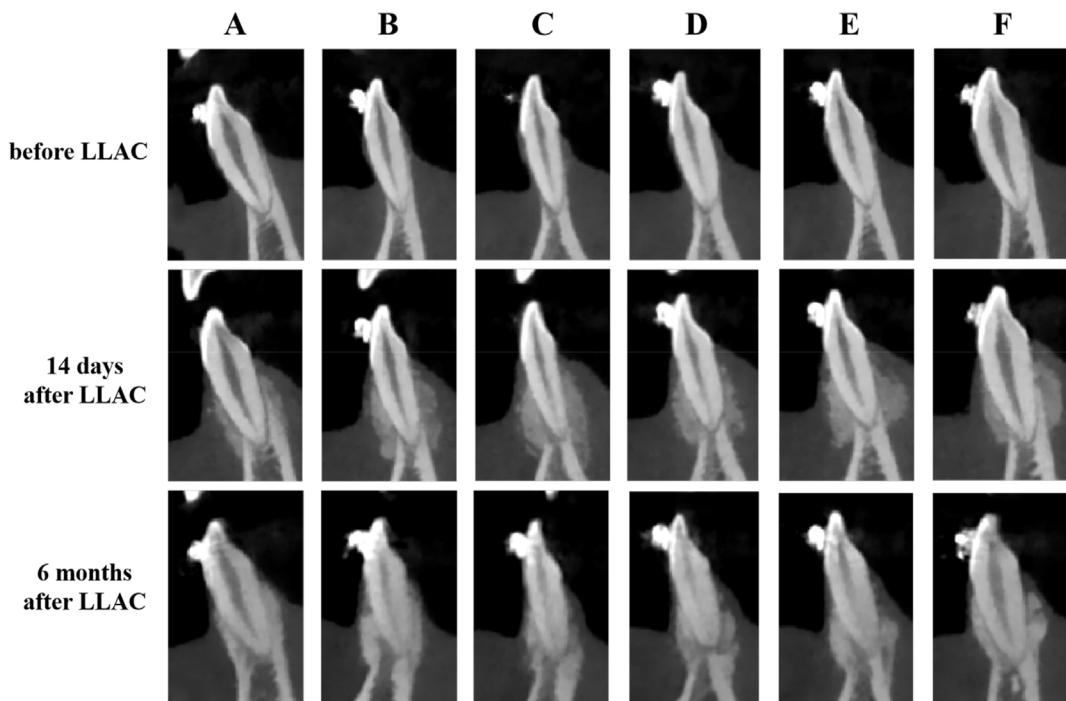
CBCT images of six lower anterior teeth of one subject before LLAC, 14 days after the LLAC, and 6 months after the LLAC. A–F: From 43 to 33. LLAC, labial and lingual augmented corticotomy.
